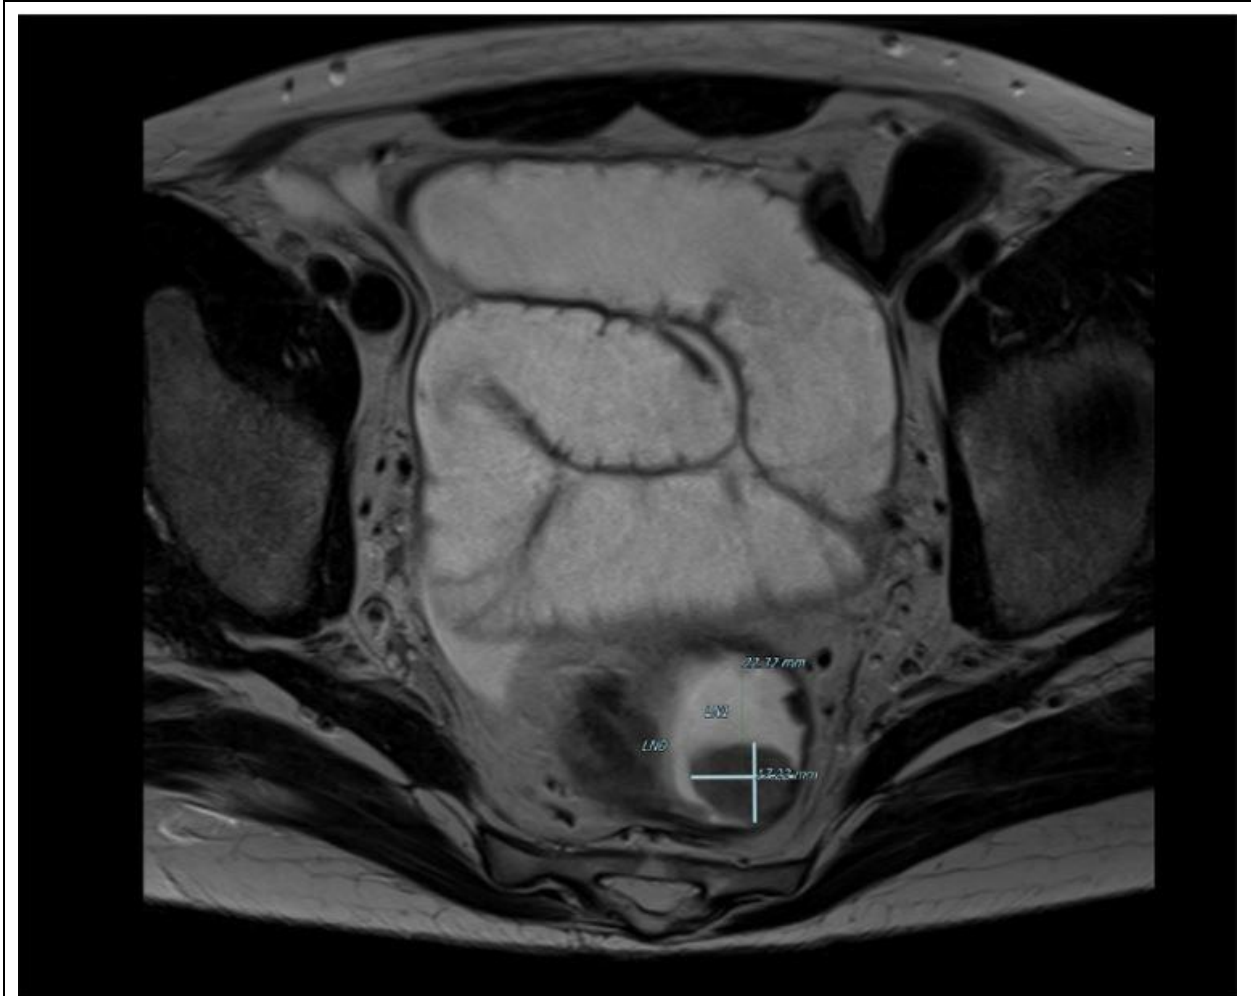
MRI picture of the rectum with T1-T2 lesions.
